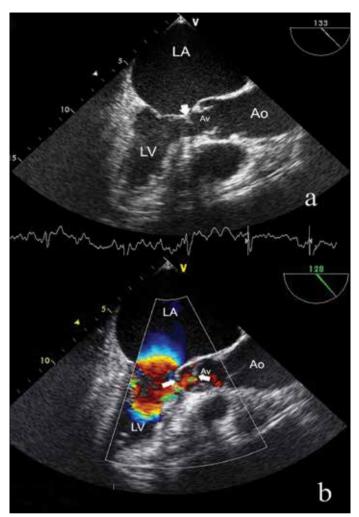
Two-chamber (120°) transesophageal echocardiography views of subaortic membrane (arrow-a) and the turbulent flow (arrow -b) in the left ventricular outflow tract
